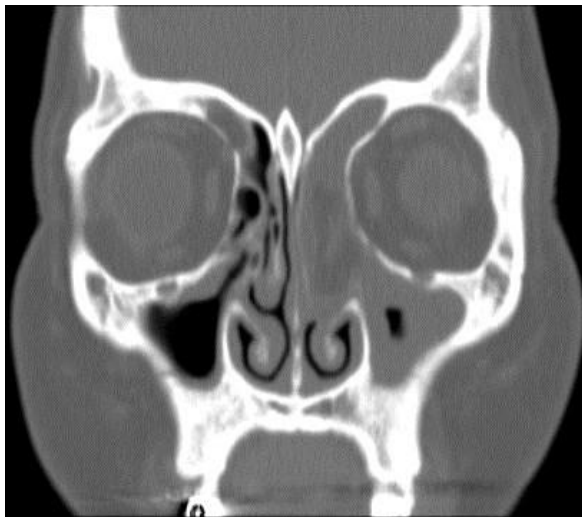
In coronal CT, the left ethmoid sinus is seen to be filled with low-density soft tissue and calcification is observed. This low-density soft tissue was found to be bone wax on surgical exploration. A soft-tissue shadow is seen on the left maxillary sinus, and the mucosa is thickened on the right maxillary sinus.
